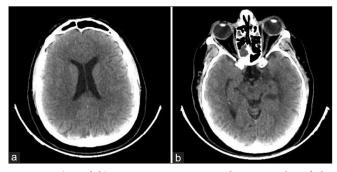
(a and b) Postoperative computed tomography of the head: Showing complete cleaning of the intraventricular abscess.
